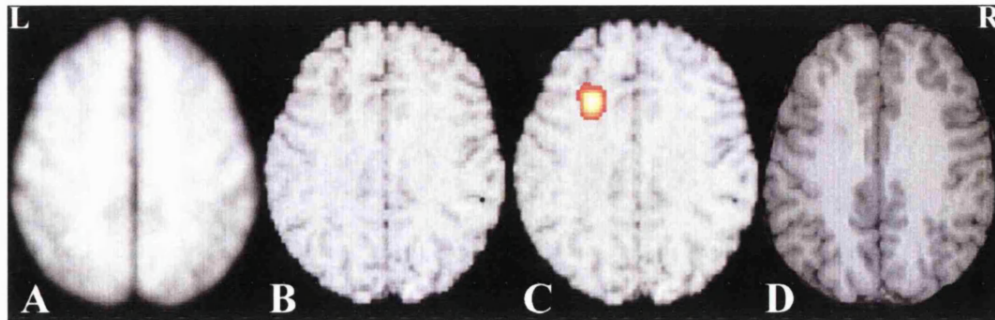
Patient 29, Patient with cryptogenic focal epilepsy and left frontal interictal epileptiform activity. Normalised axial MTR maps at the same slice position for the averaged 30 control subjects (A) and the patient (B) and (C). The region of significantly decreased MTR is superimposed on map (C). The region of decreased MTR is localised to the normal appearing cerebral tissue of the left frontal lobe. (D): The equivalent slice of the patient's T1-weighted image. The region in (D) was used for quantitative region-of-interest analysis of MTR values. Note that right on the images is patient's right.
